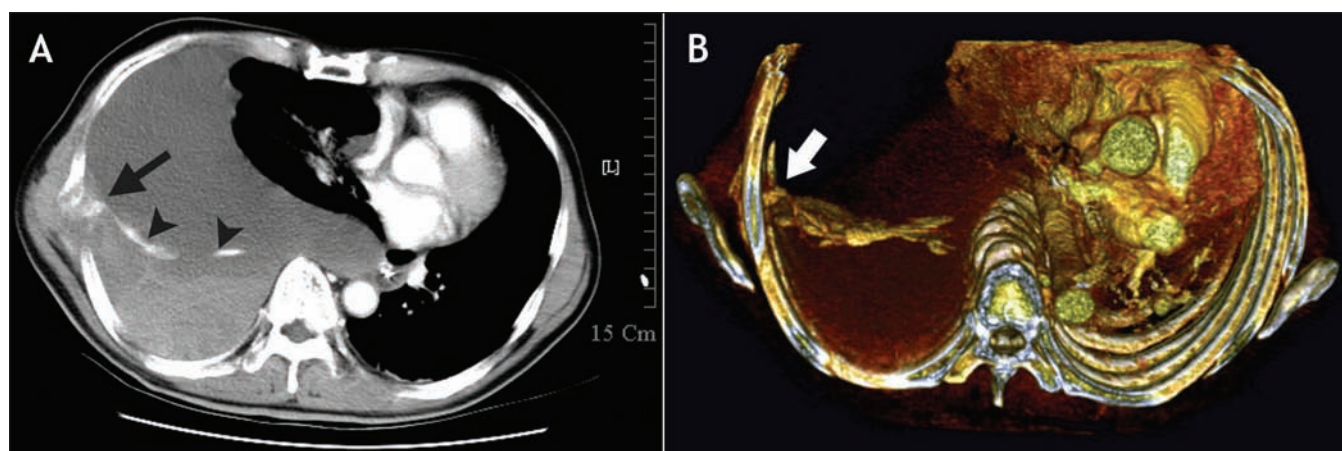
A: Chest computed tomography scan with contrast showing extravasation of the contrast medium (arrow) from a rib tumour and a sheet (arrowheads) separating different density pleural fluids. B: Coloured 3-dimensional reconstruction of the computed tomography scan showing the bleeding site (arrow).
